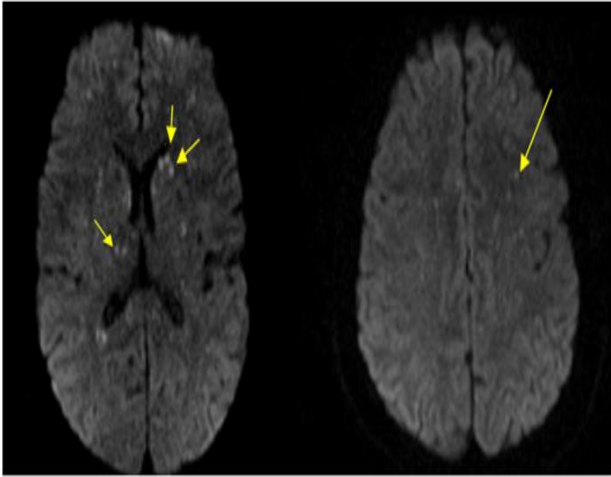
MRI brain shows non hemorrhagic infarcts (yellow arrows) over bilateral cerebral hemispheres.
